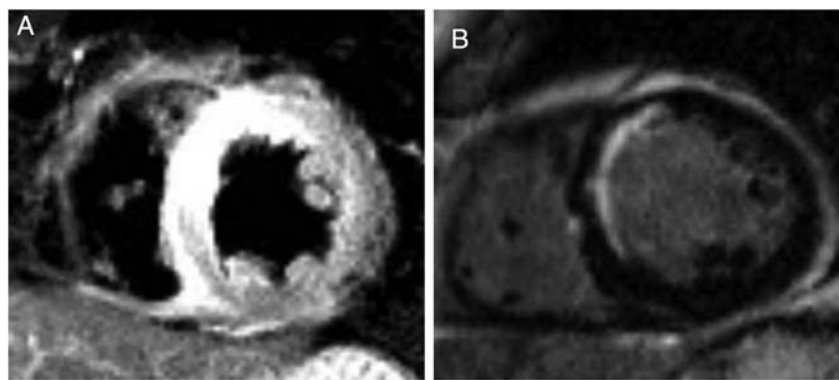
Examples of T2-weighted and delayed enhancement images. A T2-weighted image used for area at risk analysis (A) and a delayed enhancement image used for final infarct size analysis (B) taken from a patient with a lesion in the left anterior descending artery.
